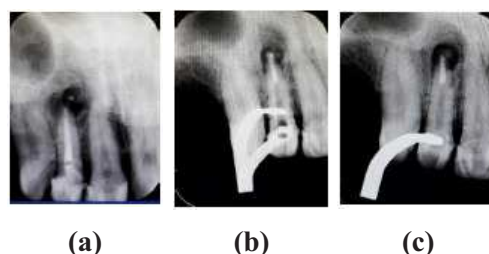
(a) Radiograph showing periapical evaluation and the condition of calcium hydroxide at the second visit. (b) MTA apical plug. (c) Radiograph showing 1 week follow-up post application of MTA plug.
